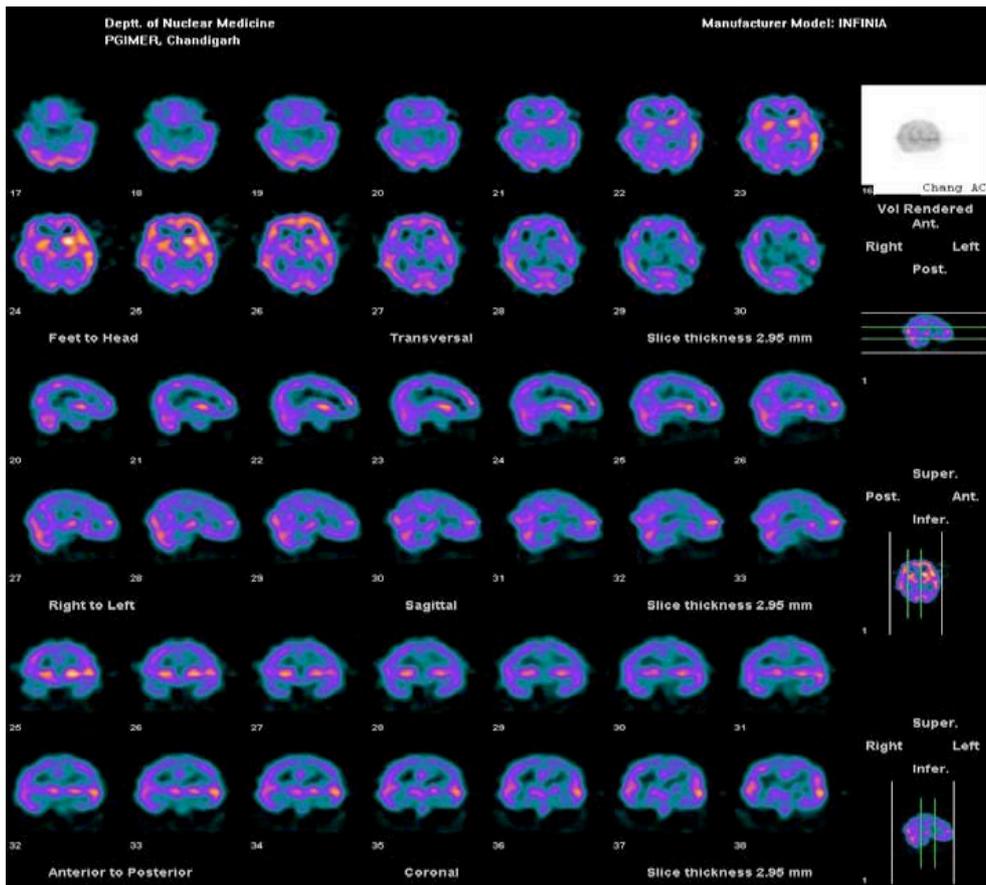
Pre-operative SPECT showing negligible perfusion in left posterolateral occipital lobe and mildly reduced perfusion in left inferior temporal lobe.
